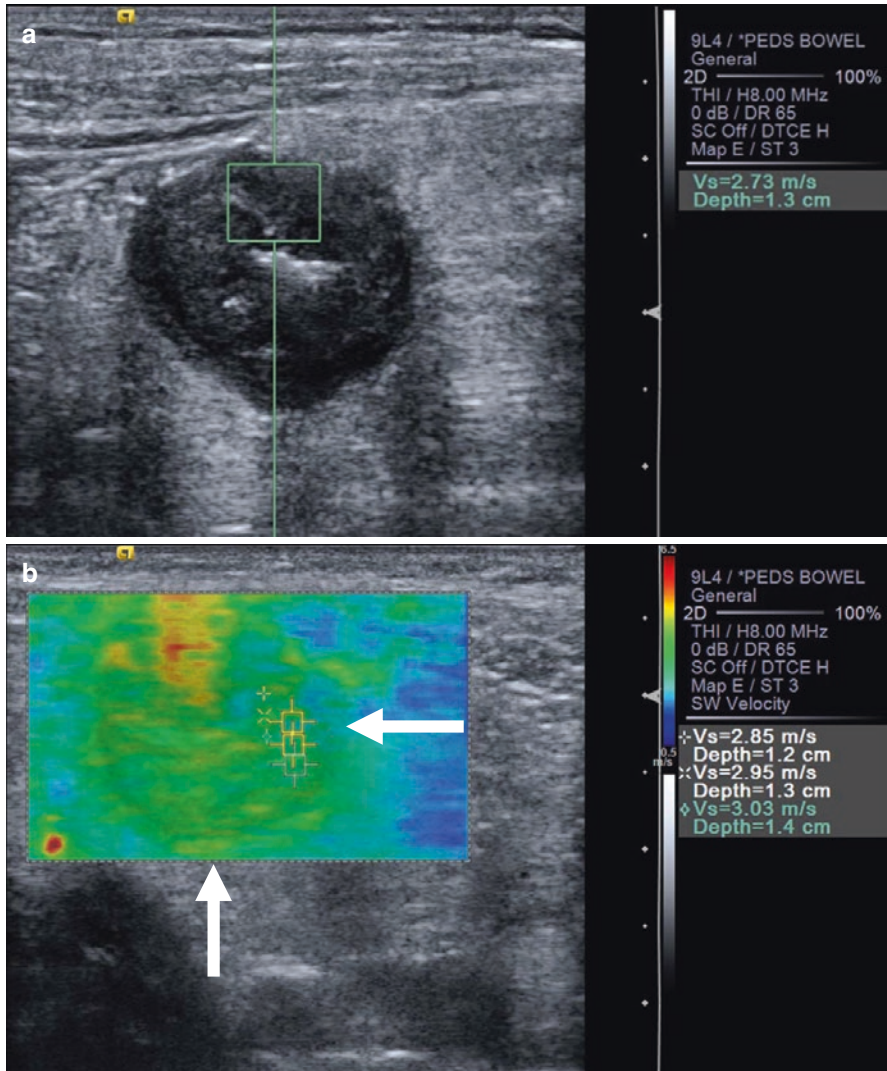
A 13-year-old boy with Crohn's disease. (a) There are marked terminal ileal wall thickening, luminal narrowing, and adjacent mesenteric fatty thickening. Point ultrasound shear wave elastography assessment shows abnormal bowel wall stiffening at the 12 o'clock location, with a measured shear wave speed of 2.73 m/s. (b) 2D shear wave elastography elastogram also demonstrates abnormal stiffening of the bowel wall (arrows) when compared to adjacent mesentery. Three shear wave speed measurements at the 3 o'clock location range from 2.85 to 3.03 m/s
